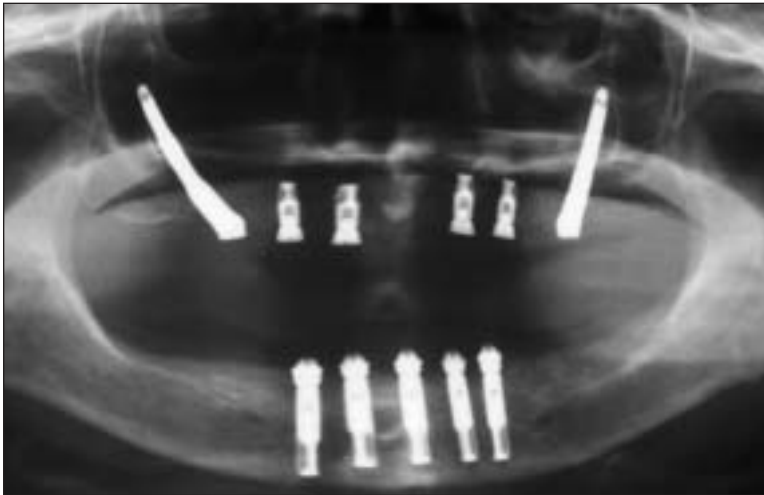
Radiograph taken after implant placement (patient 4). Zygomatic implants were placed bilaterally.
